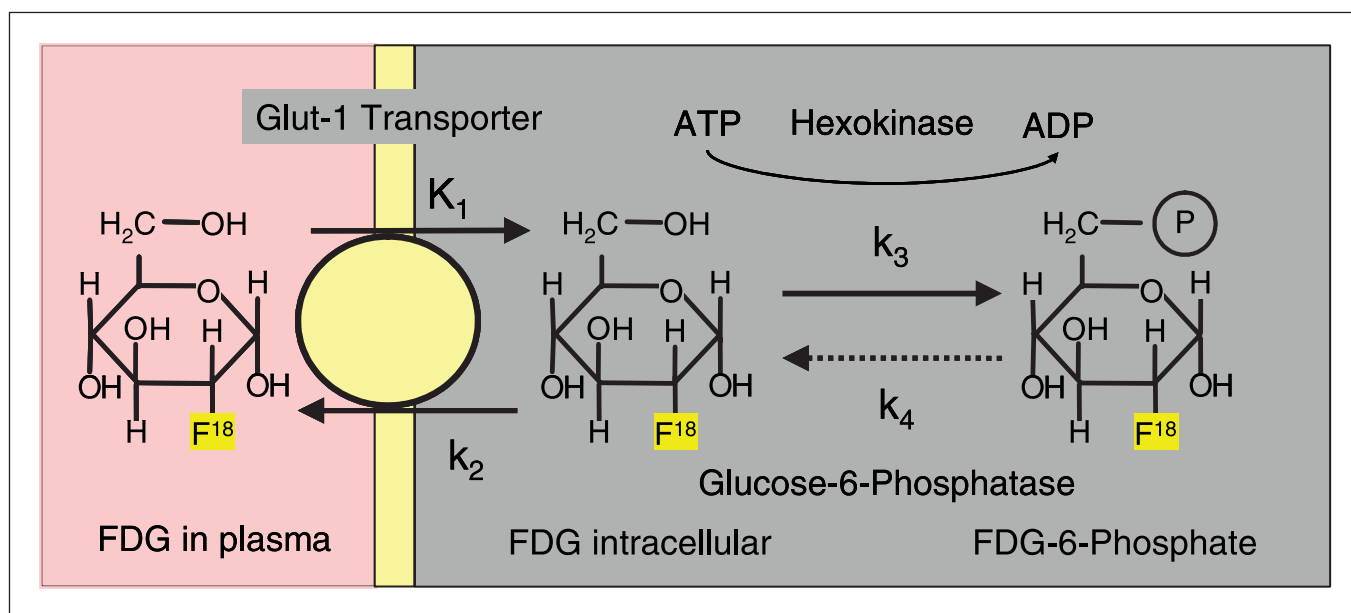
Transport and metabolism of FDG. Following facilitated transport by GLUT-1 (K_1), FDG is phosphorylated by hexokinase (k_3). FDG-6-phosphate can neither undergo further metabolism nor diffuse out of cells. As the dephosphorylation (k_4) reaction also occurs slowly, FDG-6-phosphate is trapped intracellularly and accumulates.
